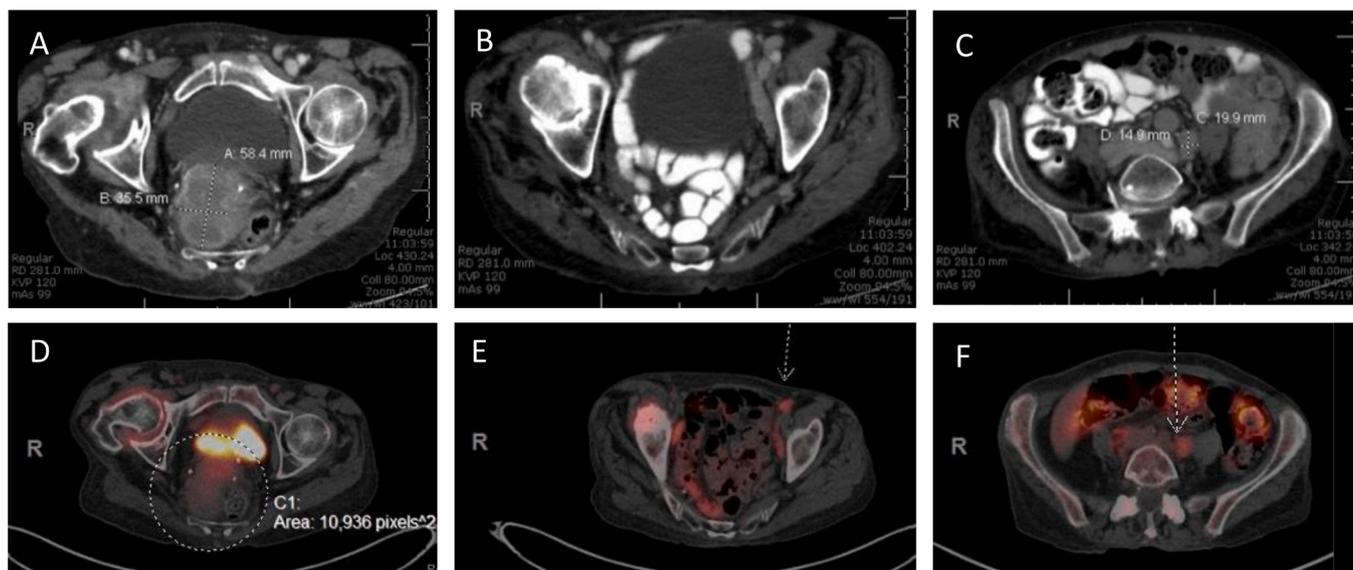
Radiologic findings for case report 1, primary uterine mass with diffuse lymphadenopathy. (A) Axial CT showing heterogenous uterine mass measuring approximately 6×5 cm. (B) Axial CT showing prominent external iliac and inguinal lymph nodes. (C) Axial CT showing enlarged left common iliac lymph node measuring approximately 1.5×2 cm. (D) Axial PET/CT FDG showing heterogenous FDG uptake in the uterine mass and increased metabolic activity in the right hip. (E) Axial PET/CT FDG showing a hypermetabolic left external iliac lymph node. (F) Axial PET/CT FDG showing a hypermetabolic left common iliac lymph node.
